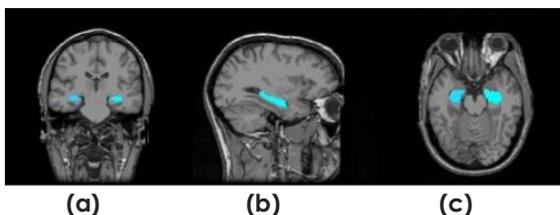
The Hippocampal area for some relevant blue slice on the (a) coronal view (b) sagittal view (c) axial view for AD subject from MRI scan
